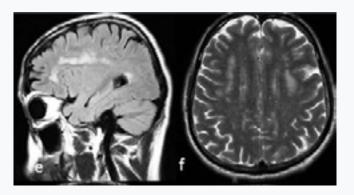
e. Signal pathologies in periventricular location and tendency to merge in the sagittal section FLAIR sequence *f.* Signal pathologies in bilateral frontoparietal subcortical location in axial T2 sequence at vertex level
